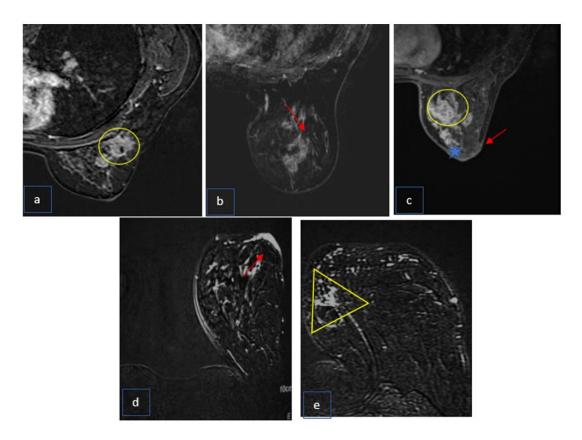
MRI aspects during Paget's disease. a: mass-like enhancement (mass) + areolar plaque enhancement (arrow), b: non-mass-like enhancement, c: mass (circle)+ non-mass-like enhancement (star) and plaque thickening (arrow), d and e areolar plaque is (red arrow) + ductal non-mass-like enhancement (triangle).
